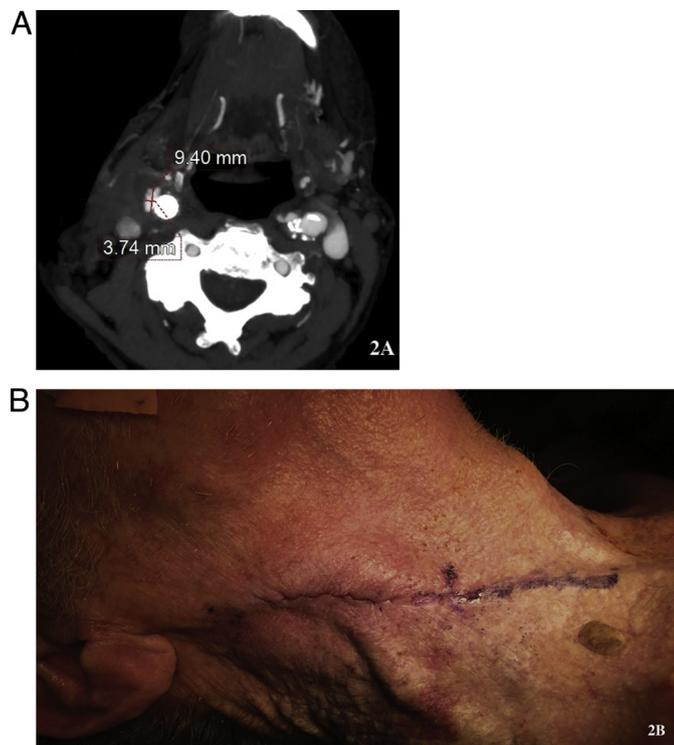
Patient's Follow up (A). CTA scan five days post-procedure revealing a significant obliteration of the pseudoaneurysm. (B) Photograph of the patient's right neck after the wound debridement and closure.
